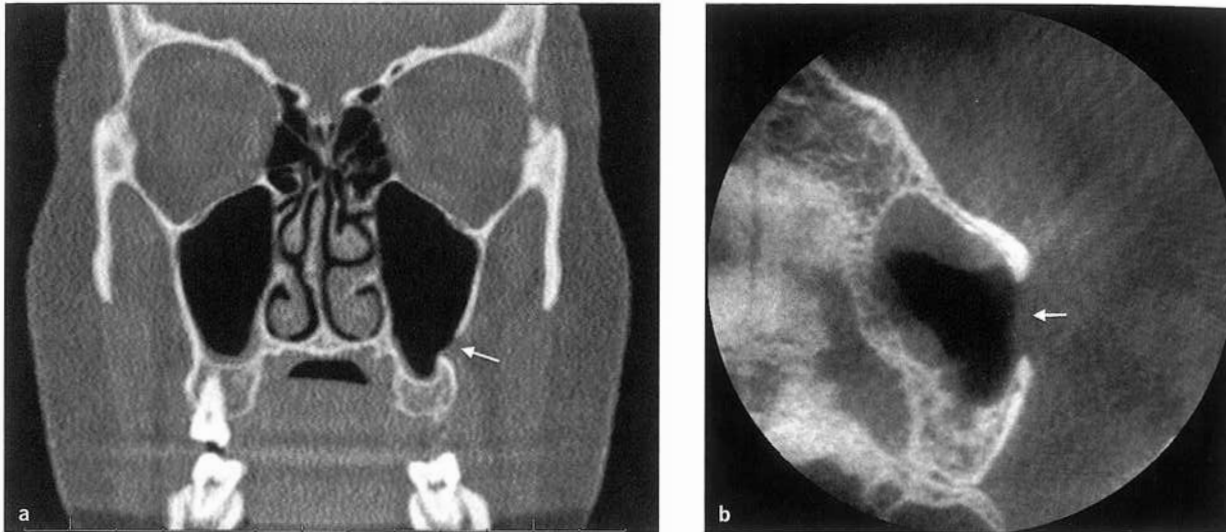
Fibrous scar tissue defect in the lateral antral wall. (a) Coronal sinus CT image showing lack of osseous healing in the lateral sinus wall following a failed periapical surgery of the maxillary left second molar 5 years prior. The tooth has been extracted, but the lateral wall scar tissue defect remains (arrow). (b) Axial CBCT image showing the same osseous defect 8 years postsurgery (arrow).
